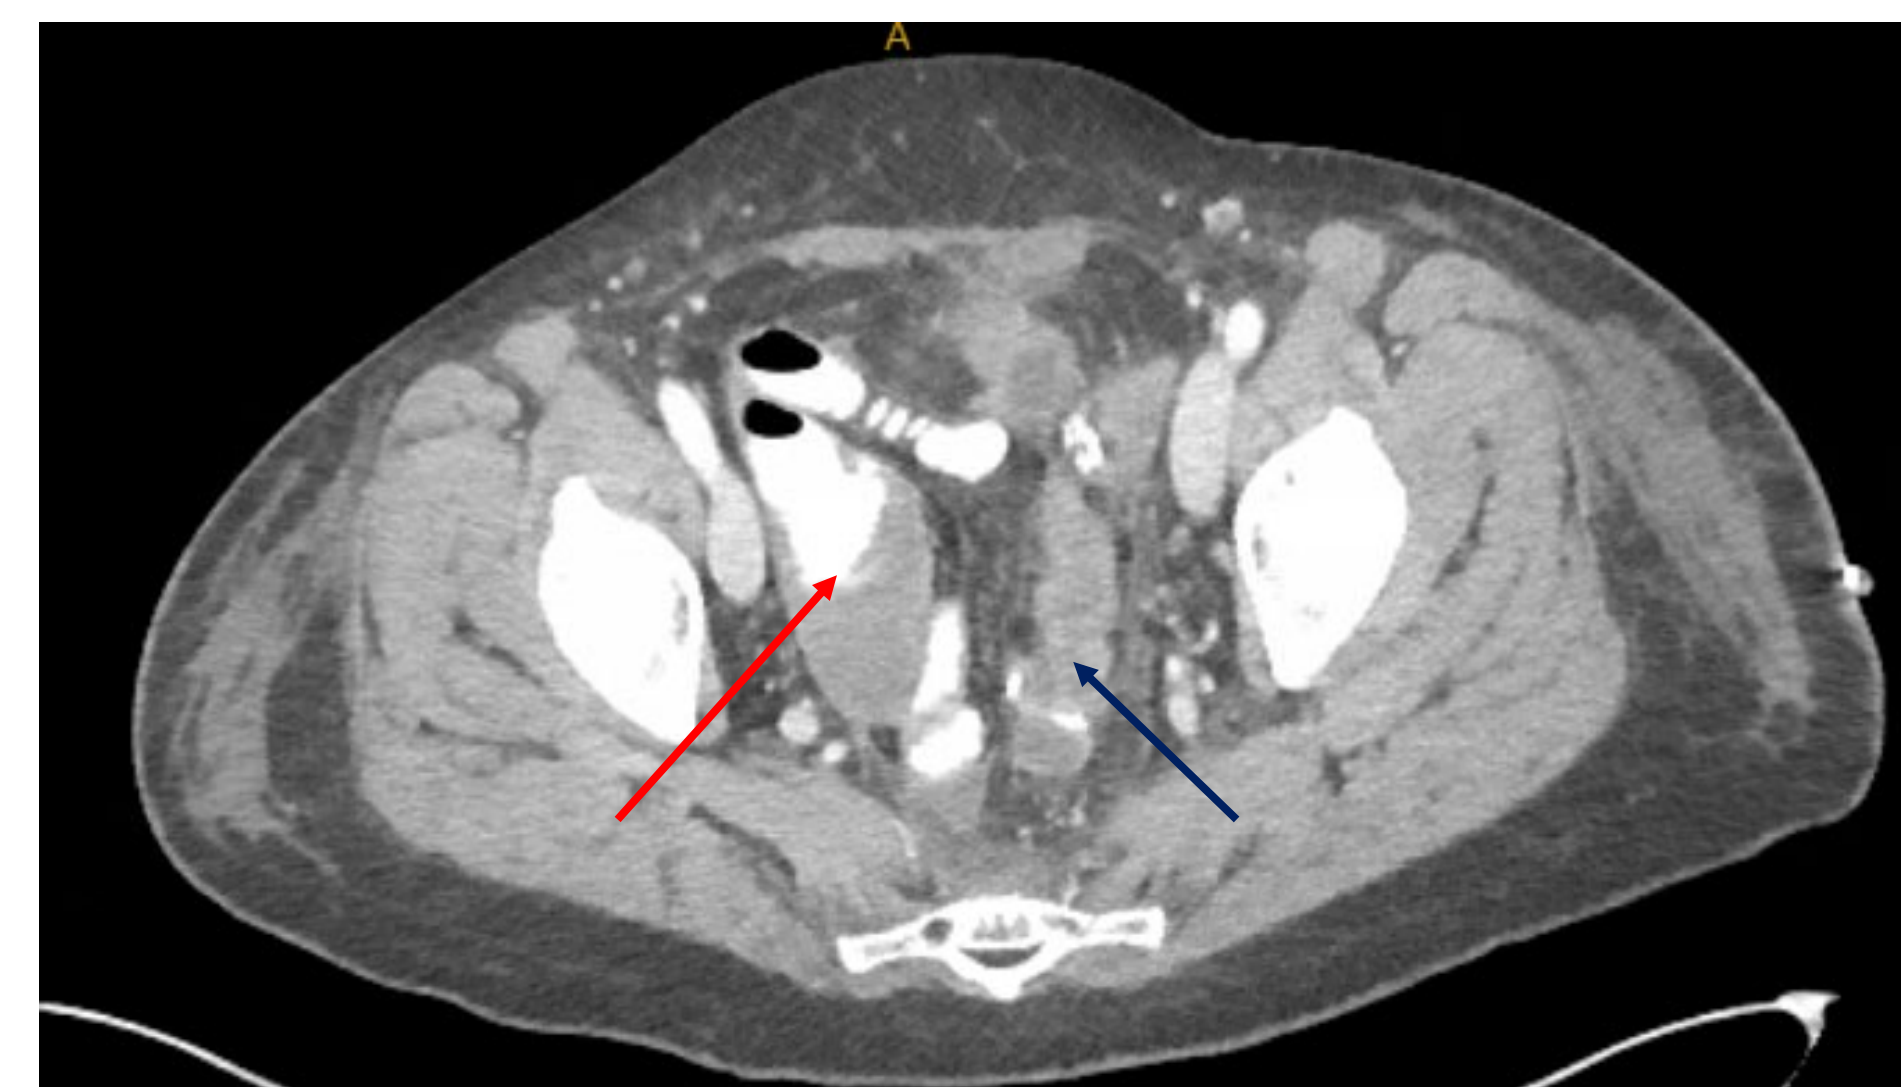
CT A/P on POD 3. RLQ fluid collection (red arrow). Staple line (navy arrow)
